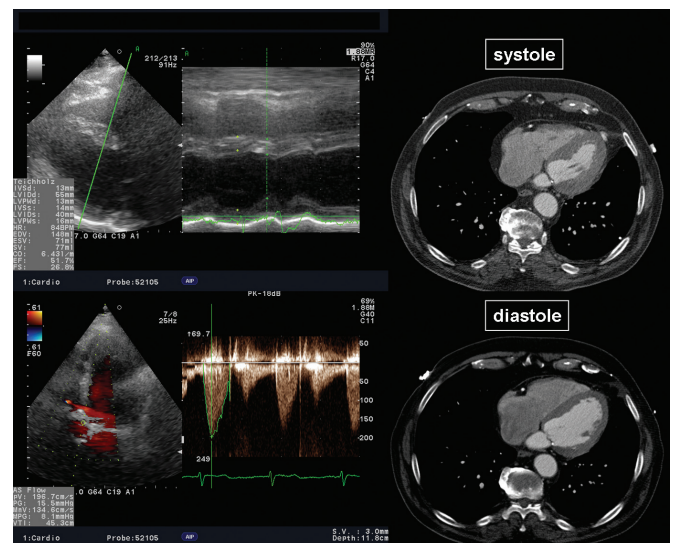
Computed tomography and transthoracic echocardiography examinations performed 26 months after surgery. The results demonstrated good myocardial recovery and low pressure gradients across the prosthesis.
